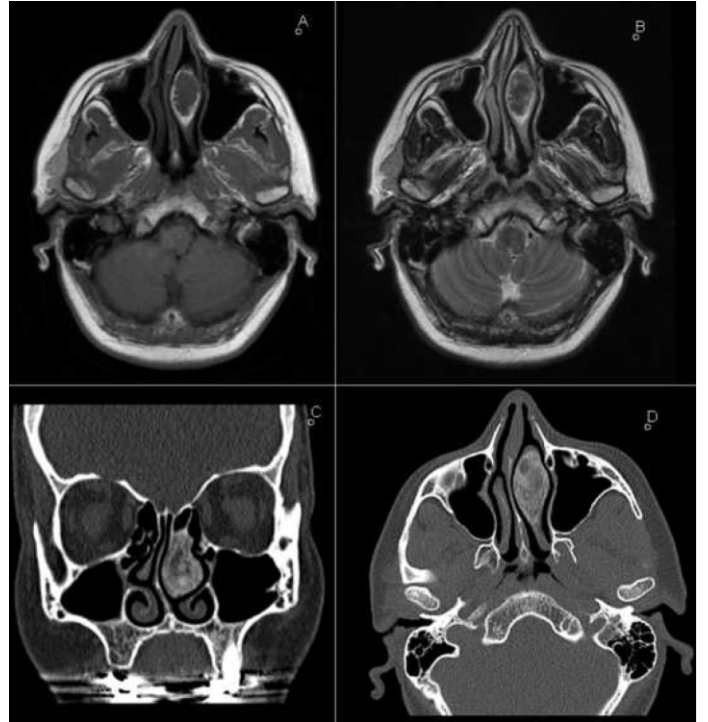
The CT scans showed ground-glass opacity of the left middle turbinate with smooth borders
